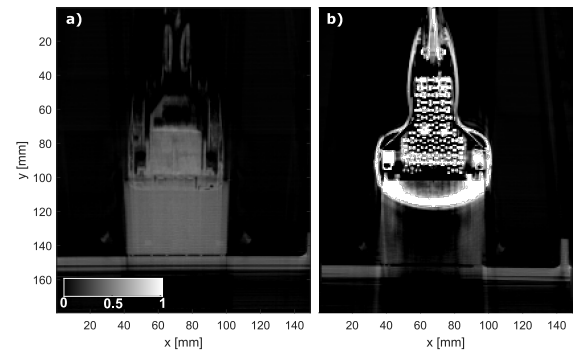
Comparative cone-beam CT imaging of freehand OpUS and conventional piezoelectric ultrasound probe. a) CBCT image of freehand OpUS probe held in empty water bath. b) CBCT image of 2D piezoelectric ultrasound probe
